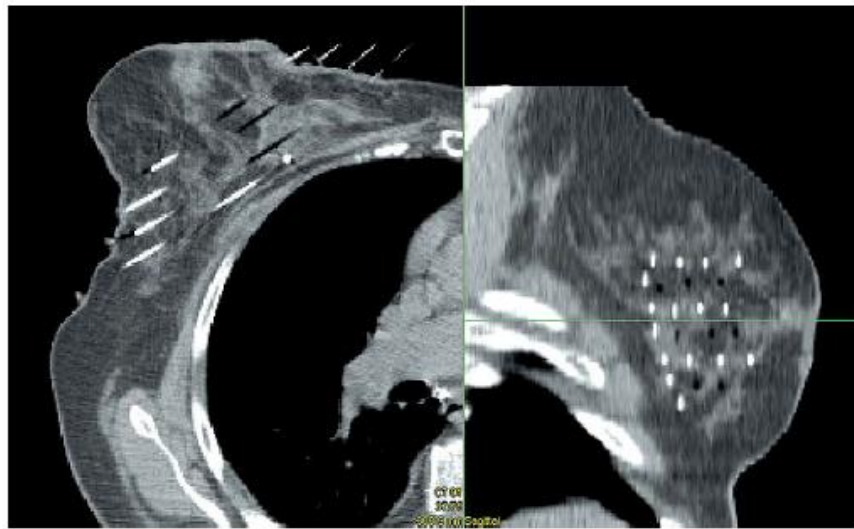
A transversal and sagittal computed tomography slice with implanted catheters. In most of the catheters, special markers are inserted (shown with the white lines/dots) but some of them do not have any markers and only the inside air makes them visible (shown with black lines/dots)¹².
